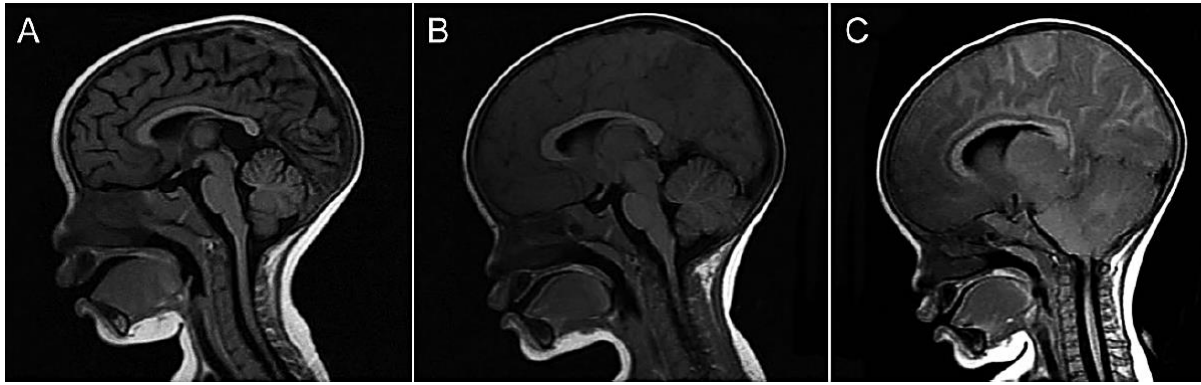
Increasing brain volume in a fatal case of paediatric cerebral malaria ([Taylor and Molyneux, 2015](#)). MRI studies show (A) brain of a recovered patient with rounded gyri in black and cerebrospinal fluid in sulci and surrounding brain stem, (B) brain of a CM affected child and (C) brain of the same child 24 hours after image B was taken. Flattened gyri and narrow sulci can be observed in both B and C. Indication of herniation can be observed in C, just 4 hours before death by the encroachment of cerebellar tonsils in the brainstem.
